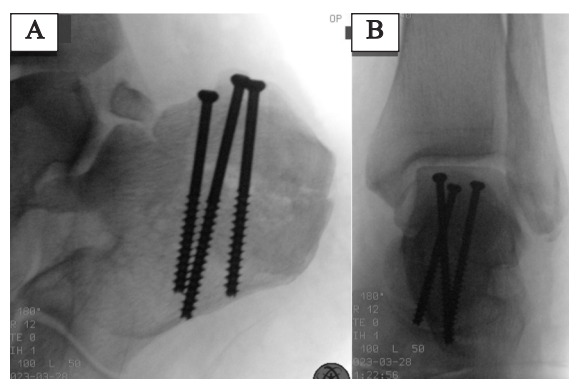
Intraoperative radiographs during reoperation, showing (A) lateral view of the calcaneus and (B) anteroposterior view of the ankle with restored alignment following re-fixation.
